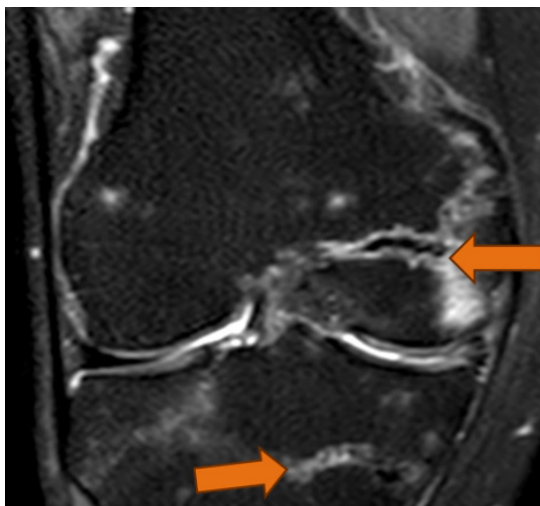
MRI of the right knee, STIR sequence. A fracture of the medial femoral condyle with associated bone marrow edema, and a bone infarction located in the tibial metaphysis.
